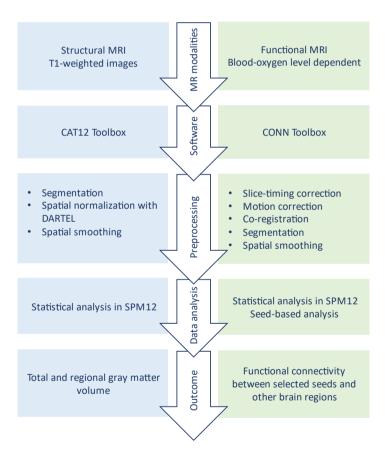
Overview of the MRI data analysis. Two MRI modalities were used in the current PhD thesis. Structural MRI was used to assess alterations in the gray matter volume, and functional MRI was used to assess brain connectivity of regions involved in sensory processing to other brain areas. Abbreviations: CAT12: Computational Anatomy Toolbox, MRI: magnetic resonance imaging, SPM12: Statistical Parametric Mapping.
